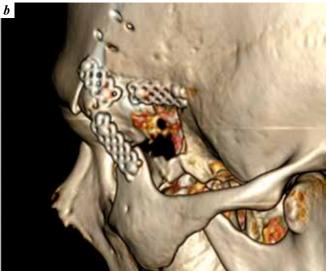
Postoperative computed tomography of the patient T., 3D reconstruction: a – frontal view; b – lateral view
